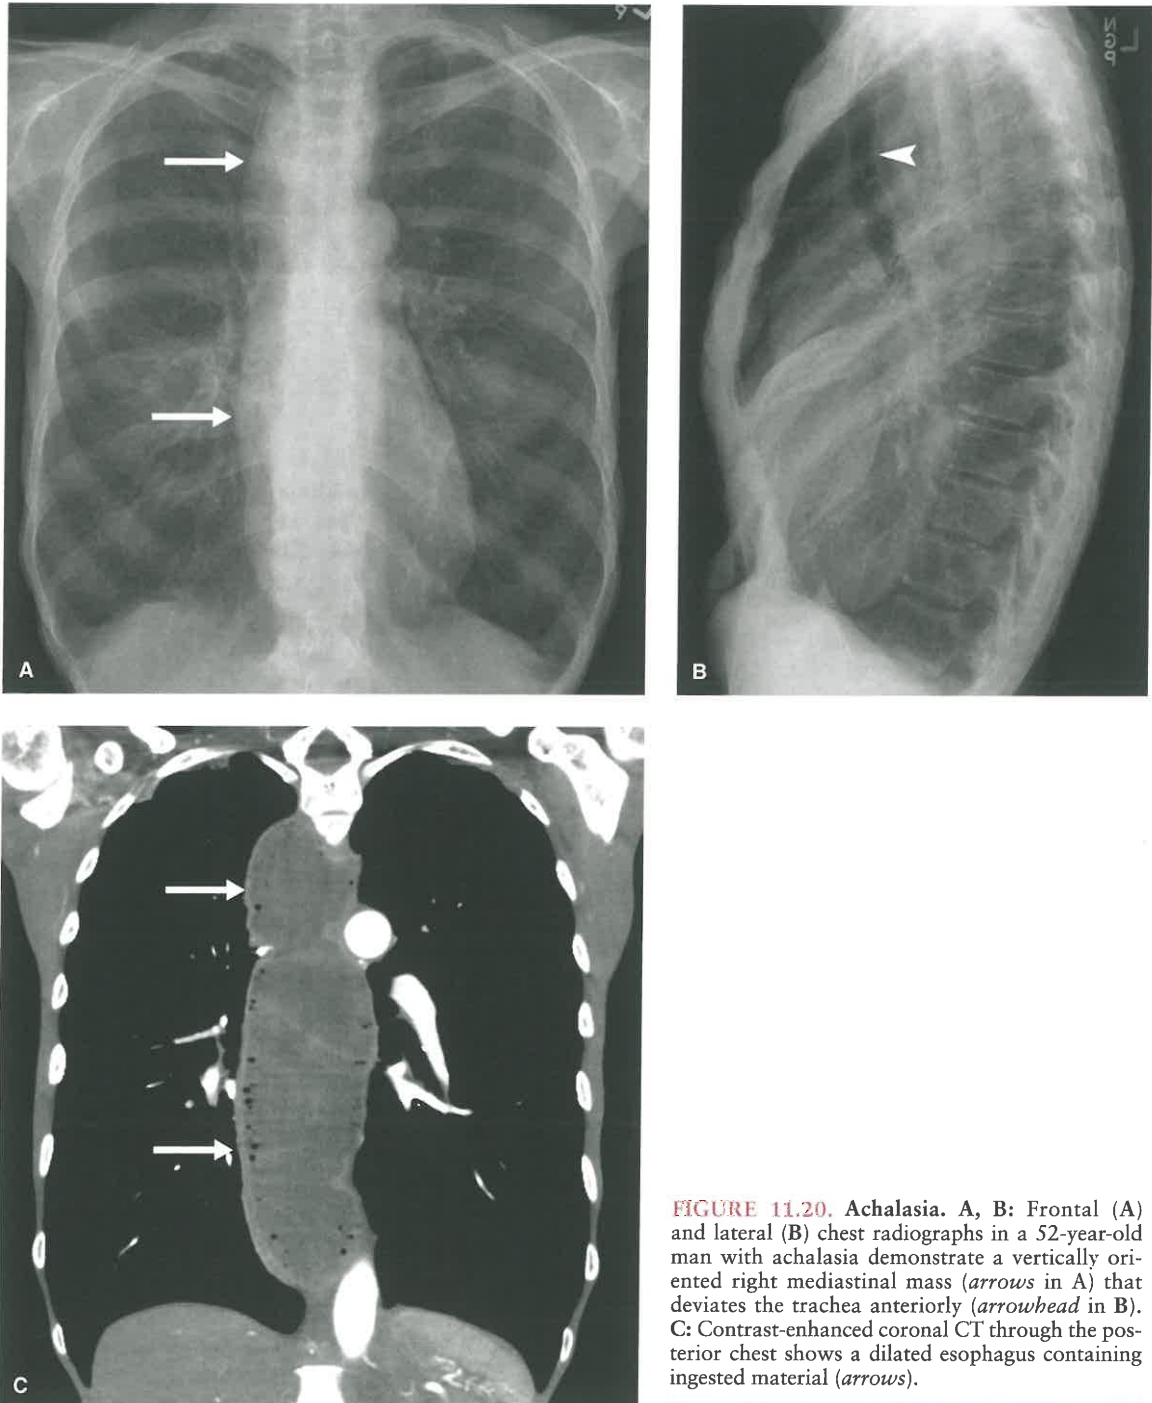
Achalasia. A, B: Frontal (A) and lateral (B) chest radiographs in a 52-year-old man with achalasia demonstrate a vertically oriented right mediastinal mass (arrows in A) that deviates the trachea anteriorly (arrowhead in B). C: Contrast-enhanced coronal CT through the posterior chest shows a dilated esophagus containing ingested material (arrows).
